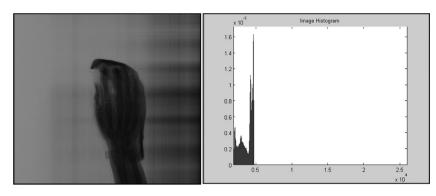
An X-ray image that could not be segmented with grayscale thresholding.
